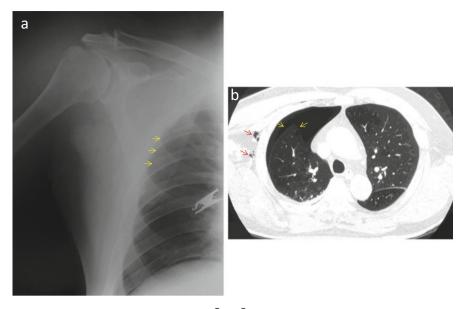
Pneumothorax and subcutaneous emphysema after arthroscopic rotator cuff repair. (a) Case 7. A 84-year-old man. Arthroscopic rotator cuff repair was performed for the medium-sized rotator cuff tear. The surgical time was 93 min. Pneumothorax (*yellow arrow*) and subcutaneous emphysema (*red arrow*) were present based on the X-ray image of the shoulder taken immediately after surgery. (b) Chest X-ray examination showed marked pneumothorax (*arrow*). A trocar was inserted into the pleural space by a surgeon before awakening from general anesthesia
